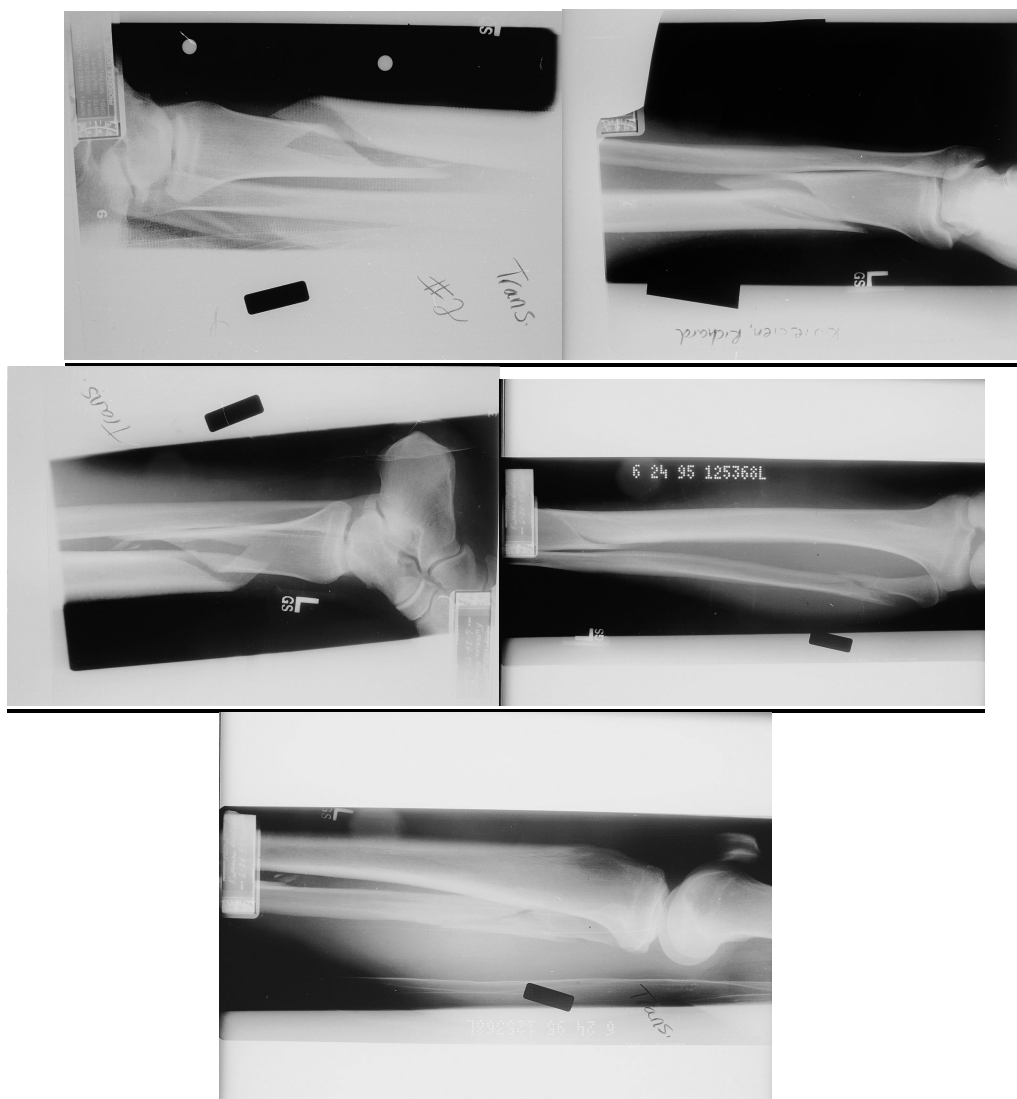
Radiographs from PWC File 8.
